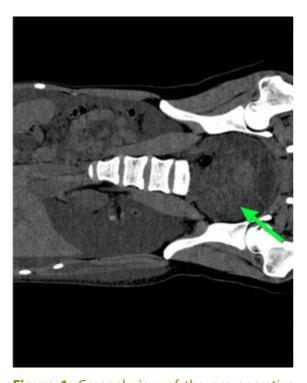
Coronal view of the pre-operative CT-TAP showing cystic and vascularised mass at the right adnexa.
